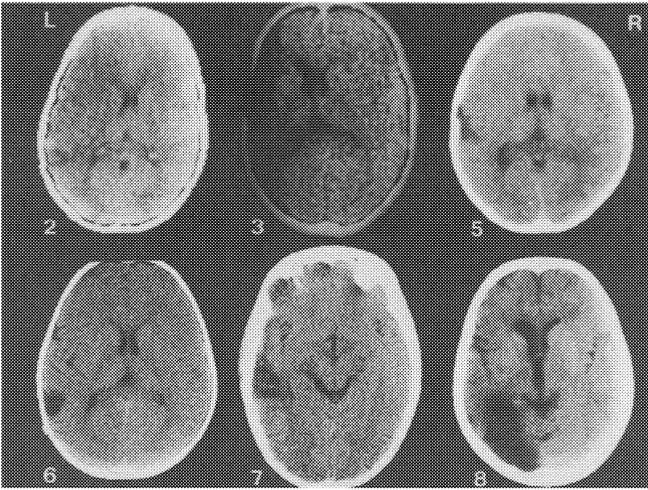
CT-scans of six patients with head injury. The numbers correspond to the case numbers in Table 1.
